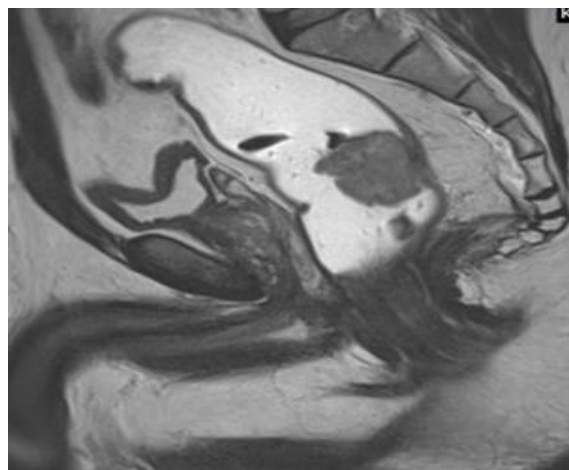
MRI T2W sagittal images showing a polypoidal morphology in T1 staging
